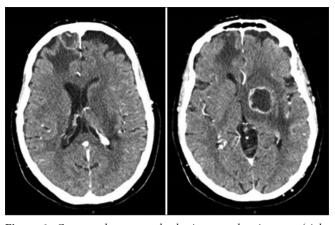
Computed tomography brain scan showing two (right frontal and left basal ganglia) ring contrast-enhancing brainoccupying lesions with associated vasogenic edema.
